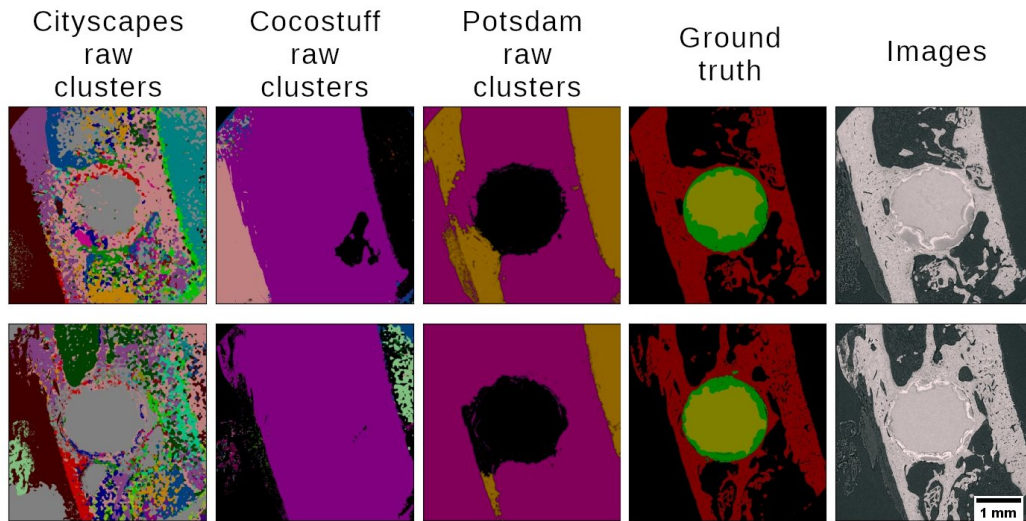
Unsupervised segmentation (without retrained segmentation head). Application of the models trained on the respective datasets to 2D slices of the SR- μ CT data of biodegradable bone implants.
